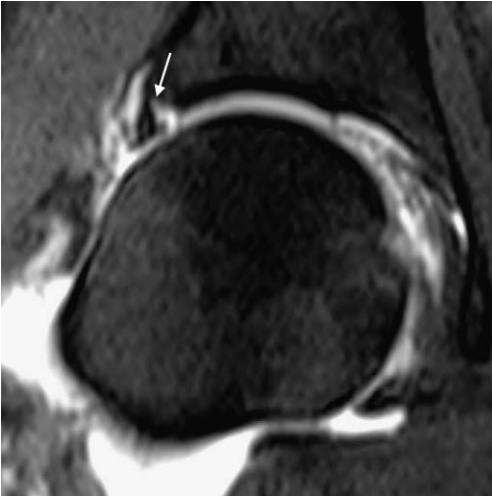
Coronal fat-saturated T1-weighted image with intra-articular gadolinium demonstrates an extensive partial detachment of the superior labrum. The arrow identifies the point at which the labrum remains attached to the rim.
